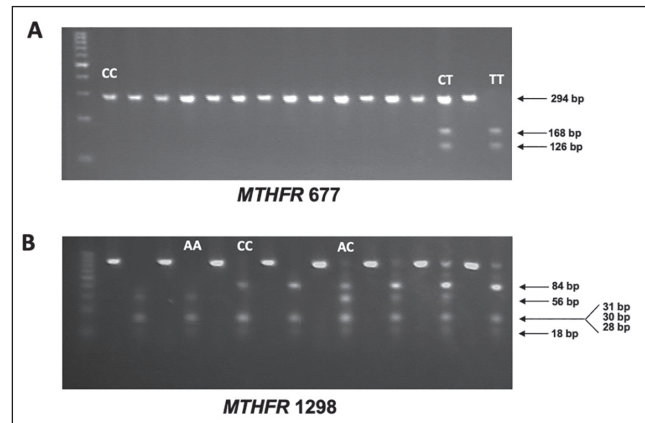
(A) PCR-RFLP findings for the *MTHFR C677T* polymorphism. The agarose gel electrophoresis depicts the results of *HinfI* digestion. The homozygous wild-type CC genotype produces a single 294 bp band, while the heterozygous CT genotype exhibits three bands at 294, 168, and 126 bp. The homozygous TT genotype displays two bands at 168 bp and 126 bp. (B) The *MTHFR A1298A* polymorphism was assessed through PCR-based Restriction Fragment Length Polymorphism (RFLP). Subsequently, agarose gel electrophoresis was employed to analyze the *A1298C* polymorphism following digestion with *MboII*. The digestion of the homozygous AA genotype resulted in five discernible bands at 56, 31, 30, 28, and 18 base pairs (bp). In contrast, the heterozygous AC genotype exhibited three bands measuring 84, 56, and 30 bp, while the homozygous CC genotype displayed four bands at 84, 31, 30, and 18 bp. The close similarity in molecular weights (31, 30, and 28 bp) rendered them indistinguishable on the gel. Predominant bands observed were at 84 bp and 56 bp. Lane 1 contained a 25 bp DNA marker.
